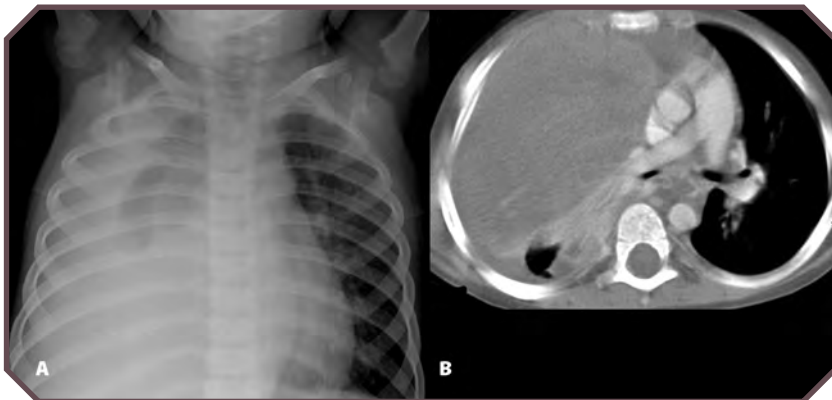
Pleuropulmonary blastoma in a 10-year-old girl with a persistent cough. A. Frontal chest radiograph demonstrates near-complete opacification of the right hemithorax, with right-to-left midline shift. B. Axial contrast-enhanced chest computed tomographic image shows a low-attenuation soft-tissue mass filling the right hemithorax.
